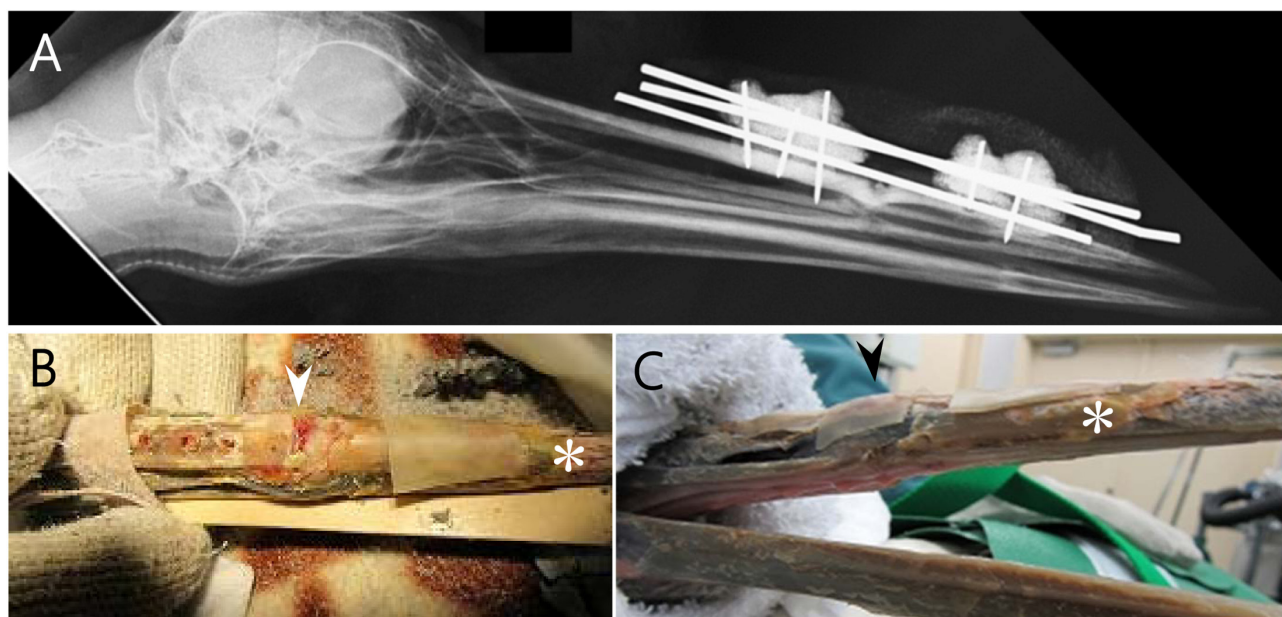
[Day 49] Surgery for removal of the external skeletal fixator (ESF). (A) A radiograph of the right side before surgery showed bone healing. (B) Cranial and (C) right-side view of the upper beak after removal of the ESF. The arrowhead shows the site of the middle upper beak fracture, and the asterisk shows the distal side of the upper beak.
